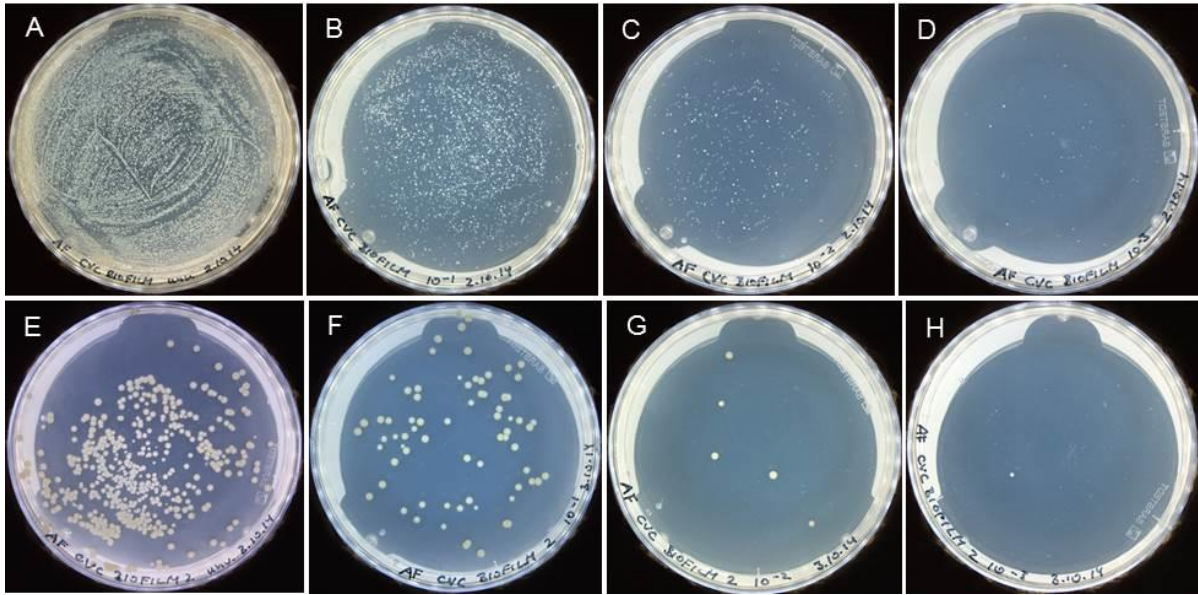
Bacterial re-isolation using the modified vortexing method and ultrasonication method. Plates with increasing dilutions (from the left to the right: undiluted to 10^{-3}) show the re-isolation capacity of the modified vortexing method (A-D) and ultrasonication method (E-H).
